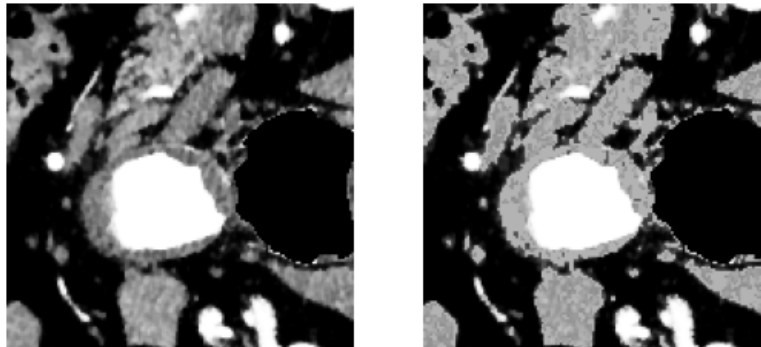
CTA before and after the pixel enhancement. (Patient 2)
